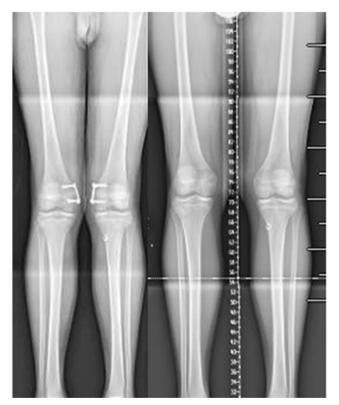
Bone length radiographs of a 14-year-old male with pre-existing bilateral valgus deformity with ACL tear s/p guided growth to correct deformity
